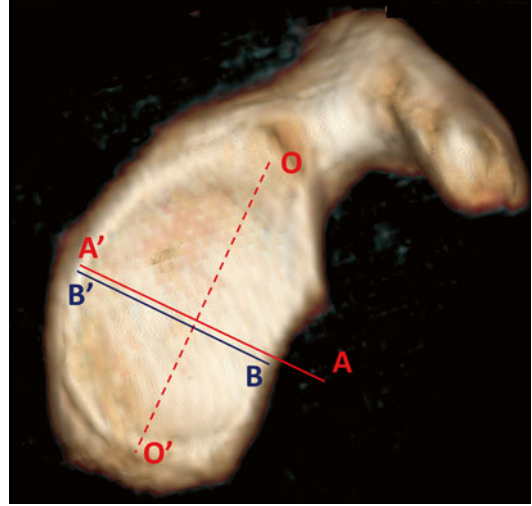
CT measurement of glenoid bone defect on 3D CT scans based on the ratio between the maximum anteroposterior width of the affected glenoid (BB') and that of the contralateral healthy glenoid (AA') (OO': maximum superoinferior length)
